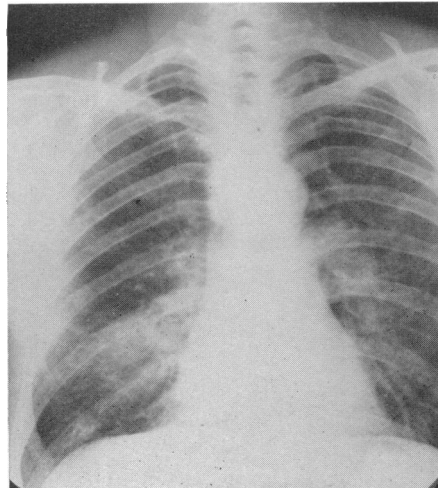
Case 3. Radiograph of chest, November, 1946.
